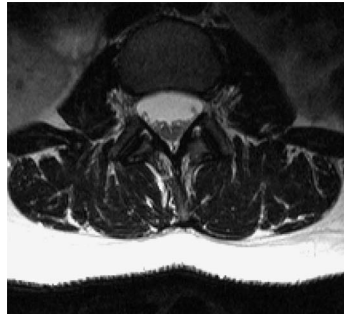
Tethered cord syndrome. a The sagittal T2-weighted image shows an enlarged lumbar spinal canal with the conus medullaris lying at an abnormally low position (L4) immediately underlying the dorsal dura mater. In this case, there were no associated anomalies such as a dermal sinus, lipoma, or meningocele. b, c The T2-weighted axial sections through the spinal canal at T12 (b) and L2 (c) reveal spinal cord at both levels. Even at the L2 level, the cord has a greater diameter than the cauda equina. It adheres to the dorsal dura mater.
